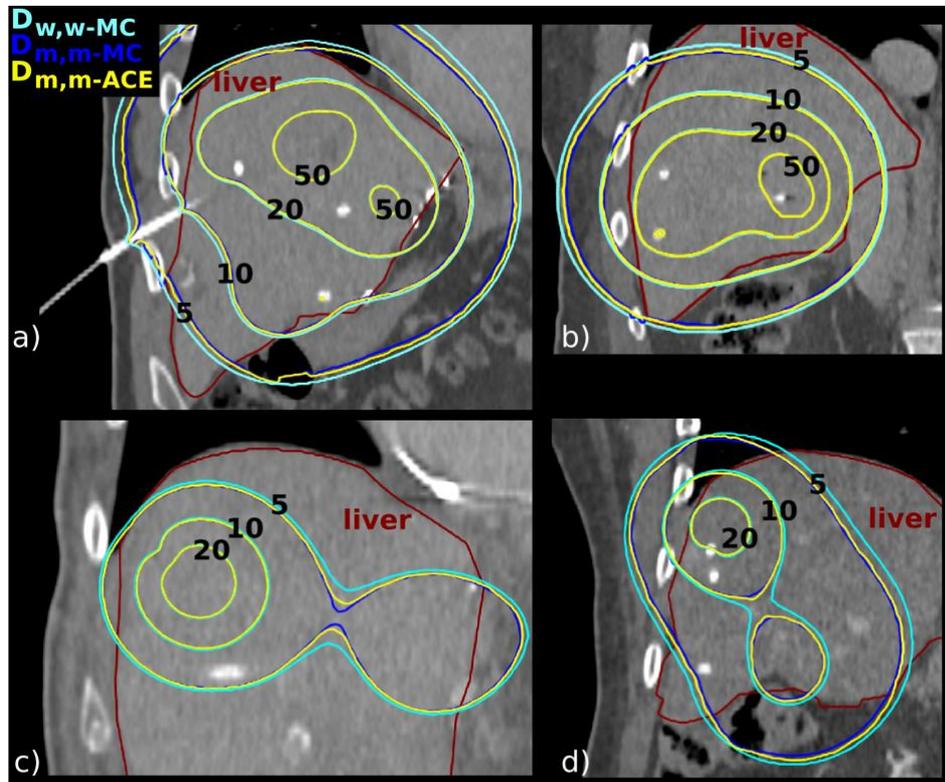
Coronal CT slices of four patients with isodose lines of MC-calculated TG-43U1 results (D_{w,w}-MC), MC-calculated TG-186 results (D_{m,m}-MC), and ACE-calculated TG-186 results (D_{m,m}-ACE). The liver contour is shown in red, dose values in Gy are shown in black.
